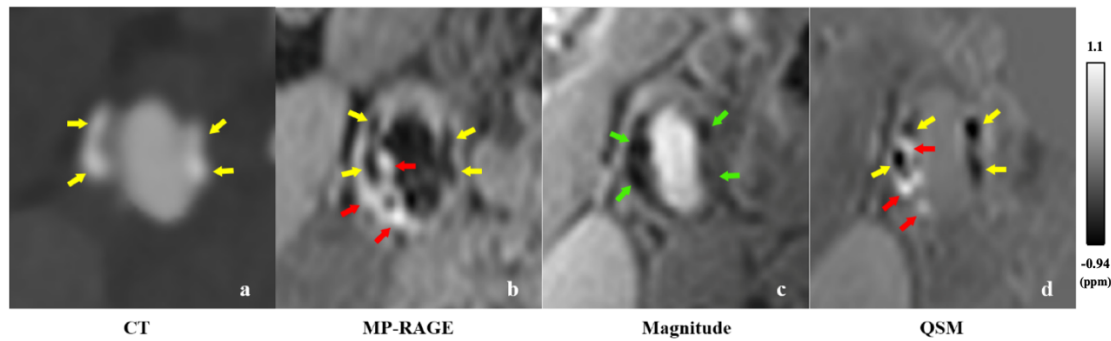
A 66-year-old male patient with right carotid atherosclerosis. CT image showing two calcified plaques (indicated by the yellow arrows) in the right carotid artery (a). MP-RAGE image showing the right carotid artery with two calcified plaques (indicated by the yellow arrows) (b). The plaque components also included IPH shown as hyperintense (indicated by the red arrows) and calcification shown as hypointense. The two sections indicated by the green arrows represent IPH and calcification that are hypointense in the SWI magnitude (c). QSM can distinguish the IPH (hyperintensity with a mean susceptibility value of 0.87 ppm compared to the adjacent arterial blood, indicated by red arrows) and calcification (hypointensity with a mean susceptibility value of -0.62 ppm compared to the adjacent arterial blood, indicated by yellow arrows) in the two sections (d). The mean susceptibility value of the vessel wall is -0.19 ppm compared to the adjacent arterial blood.
